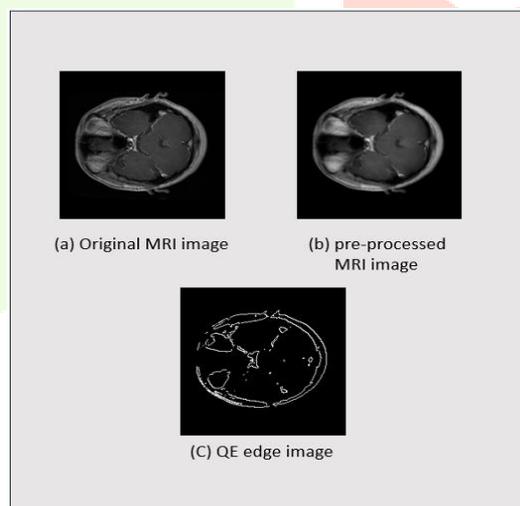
Preprocessing and QE edge detection: (a) Original MRI, (b) Preprocessed image, (c) QE edge map.
